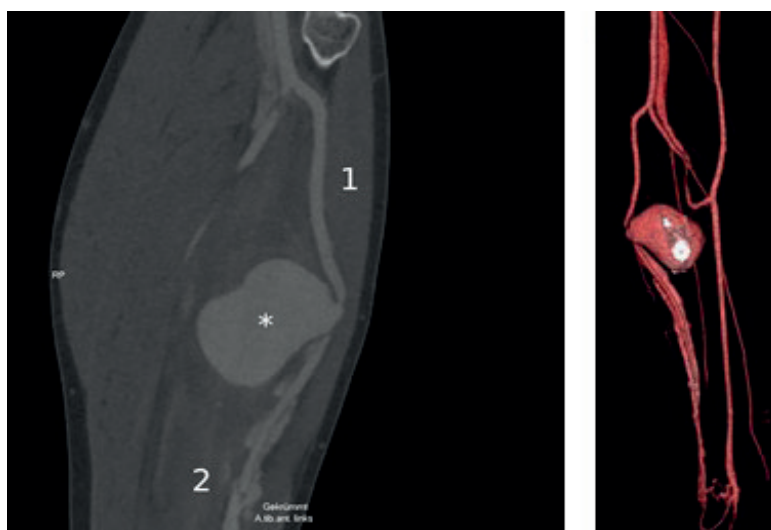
CT angiography scan of the left lower leg: (A) curved reconstruction along the anterior tibial artery, (B) 3D reconstruction: displacement of the artery by the pseudoaneurysm, contrasted deep and superficial veins (images courtesy of Radiologie 360°).
